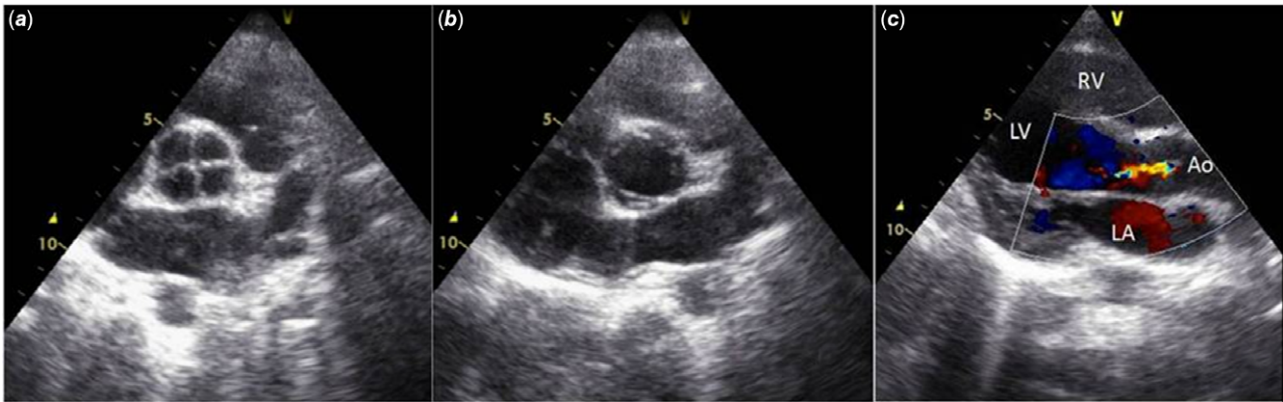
(a, b, and c) Transthoracic echocardiogram in parasternal short-axis view demonstrating (a) quadricuspid aortic valve with four equally cusps in diastole, (b) rectangular shaped opening in systole, (c) central mild aortic valve regurgitation.
